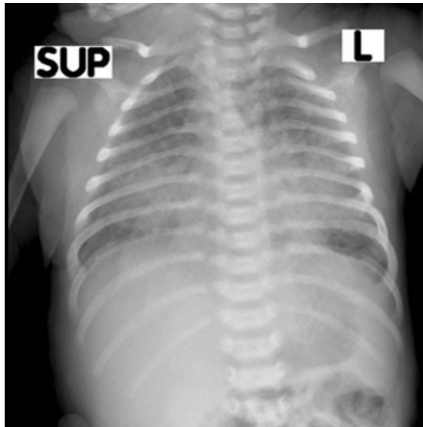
Chest x-ray showing viral pneumonitis
